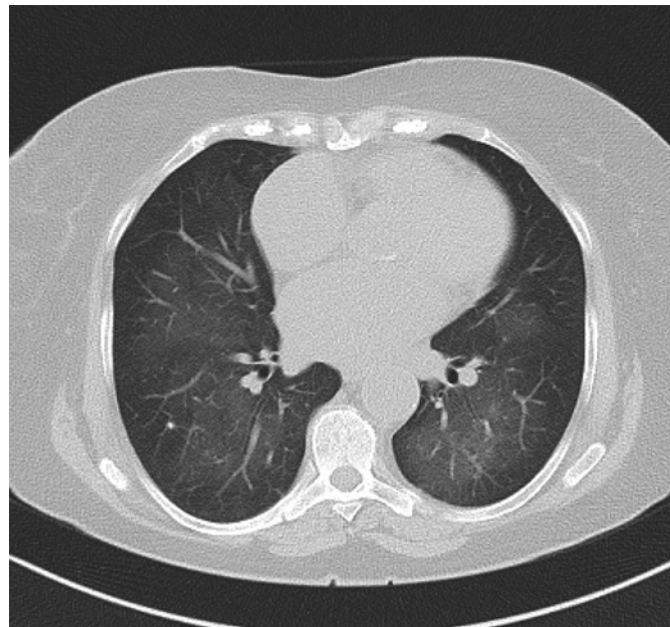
CT angiogram of the thorax performed after six sessions of plasma-pheresis, revealing an impressive decrease of the extent of DAH.
